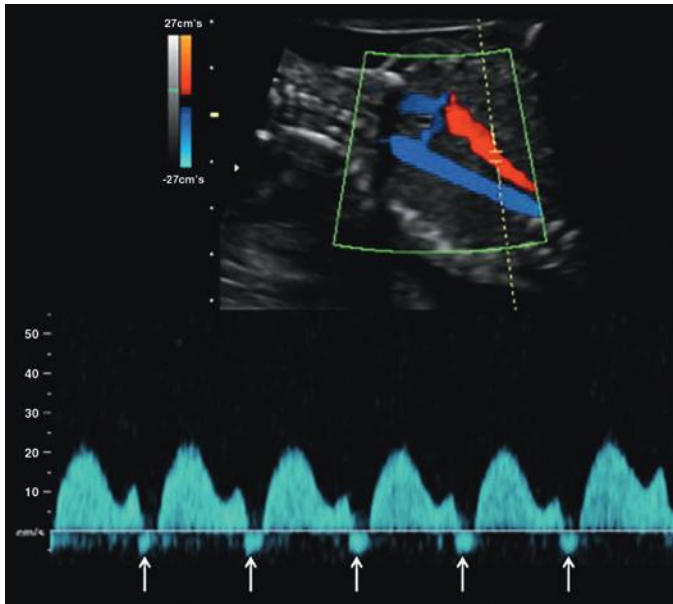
Doppler waveforms of the inferior vena cava in a normal fetus in the third trimester of pregnancy. Note the presence of reversed flow (arrows) during the atrial contraction phase of diastole.
